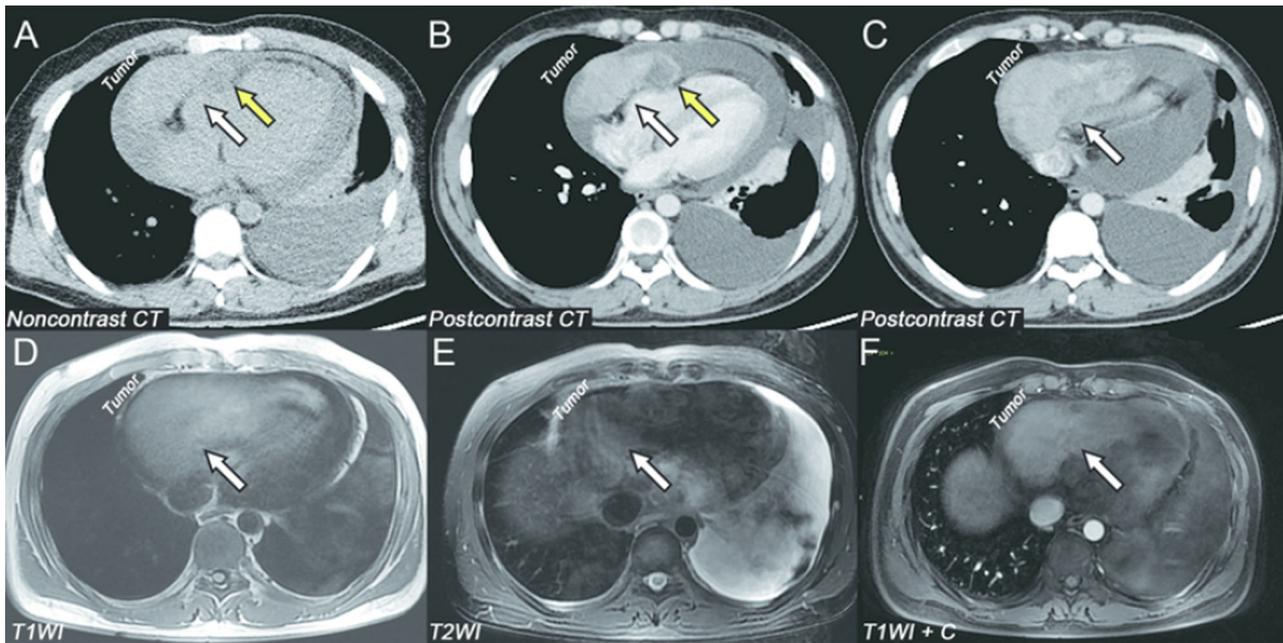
Chest computed tomography (A–C) and cardiac magnetic resonance imaging (D–F) in transverse views. Non-enhanced CT A showing a solid tumor (white arrow) with peripheral low attenuation region (yellow arrow) in the pericardium, pericardial, and left pleural effusions. Contrast-enhanced CT (B, C) showing the tumor was adjacent to the anterolateral wall of the right ventricle with unclear boundary, with homogeneous enhancement in the solid component, and no enhancement in the peripheral low attenuation region. Non-enhanced cardiac magnetic resonance imaging (D, E) showing the large poorly defined tumor was isointense to myocardium on T1WI (FIRM sequences) and hyperintense on T2WI with Fat Suppression (FS). The late gadolinium enhancement image showing the tumor with heterogeneous enhancement.
